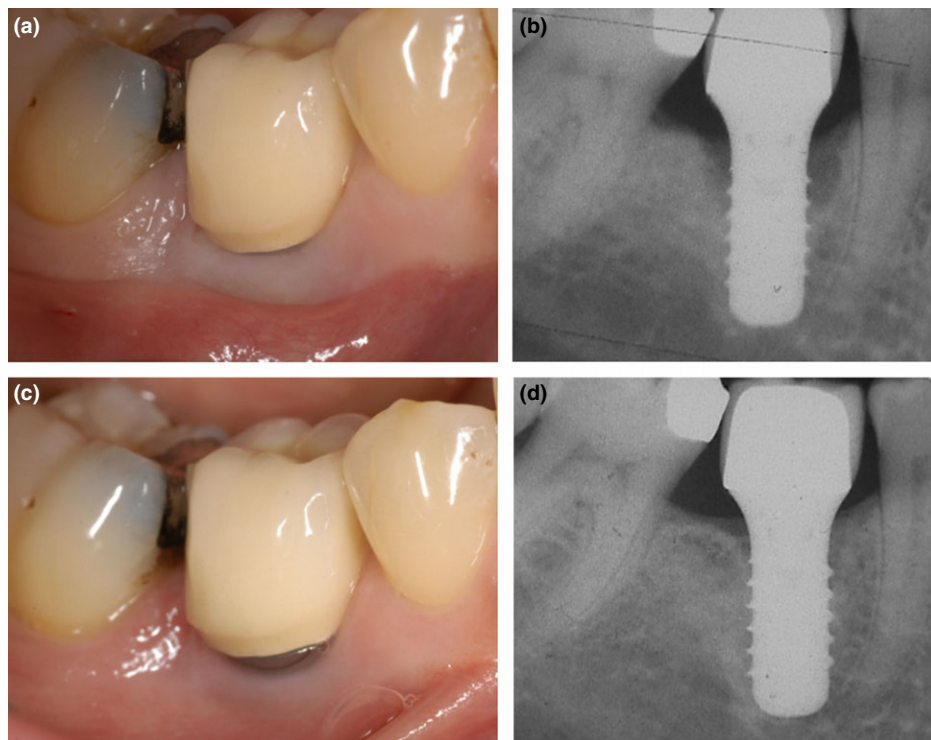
Baseline buccal view of implant 45 with PPD ≤ 9 mm, bleeding on probing (BoP) and suppuration (a); baseline radiographic bone defect at implant 45 (b); buccal view of implant 45 at the 2-year follow-up with PPD ≤ 5 mm (c); radiographic hard tissue fill at the 2-year follow-up at implant 45 (d).
